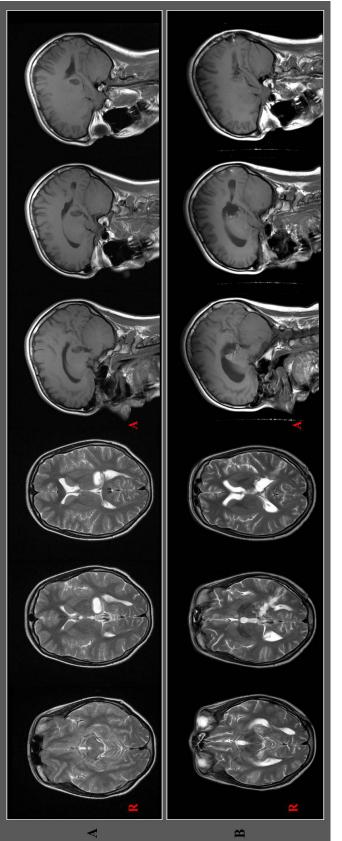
(A) Axial T2-weighted and sagittal T1-weighted MRI of the brain performed on the day of admission and prior to the operation. A tumor was visible in the left thalamus. (B) Axial T2-weighted and sagittal T1-weighted MRI performed 1 month after tumor resection showing a defect of the left thalamus and encephalomalacia in the left temporal lobe as a result of the operation.
